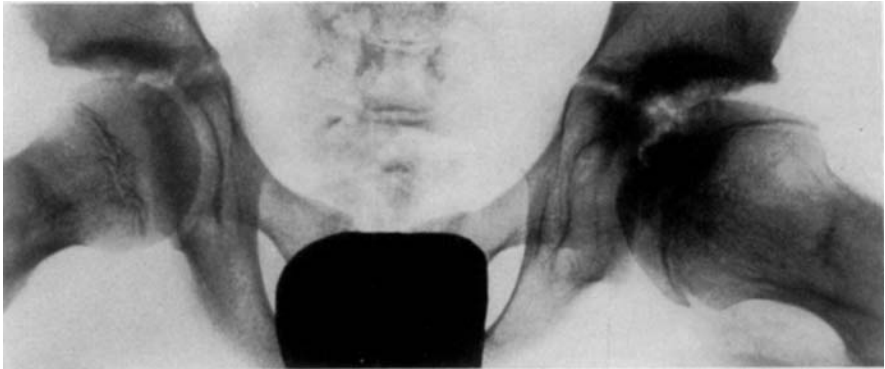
Case 140, boy aged 12 years at onset. Untreated. The radiograph shows a cap-shaped epiphysis.
